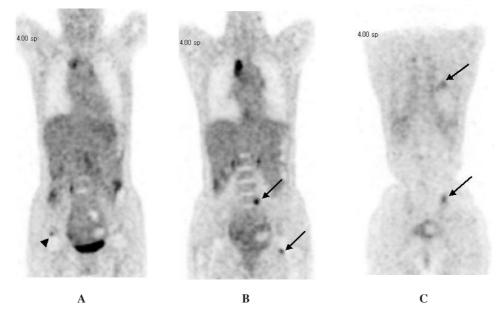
FDG-PET performed 60 minutes after intravenous injection of 250 MBq of FDG. Coronalsection images were acquired in the dorsal direction in the following order: A, B, C. Arrows point to bone metastases, and the arrowhead points to signs of osteoarthritis. A: FDG uptake by the acetabulum of the right hip joint and by the mediastinal lymph nodes. B: FDG uptake by metastases to the left side of the fifth lumbar vertebra and the medial aspect of the left femur. C: FDG uptake by the left sacroiliac joint and left dorsal ribs.
